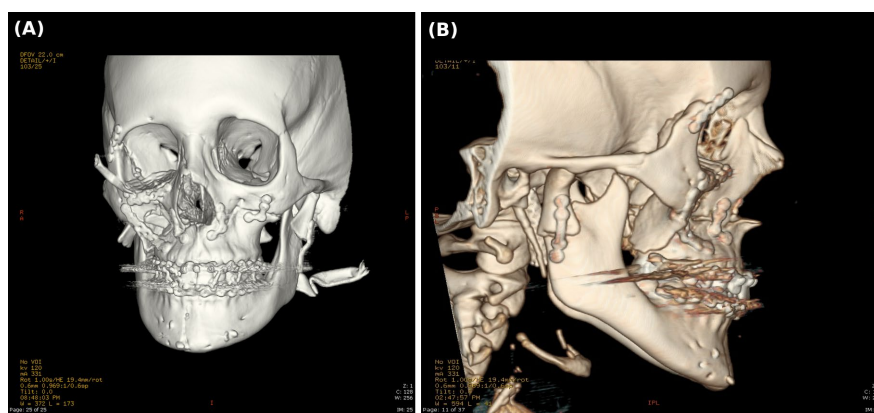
Interim three-dimensional computed tomographic reconstructions after the second facial stage. (A) Midface reconstruction and partial mandibular fixation. (B) Persistent superior displacement of the right subcondylar fracture before the third-stage procedure.
